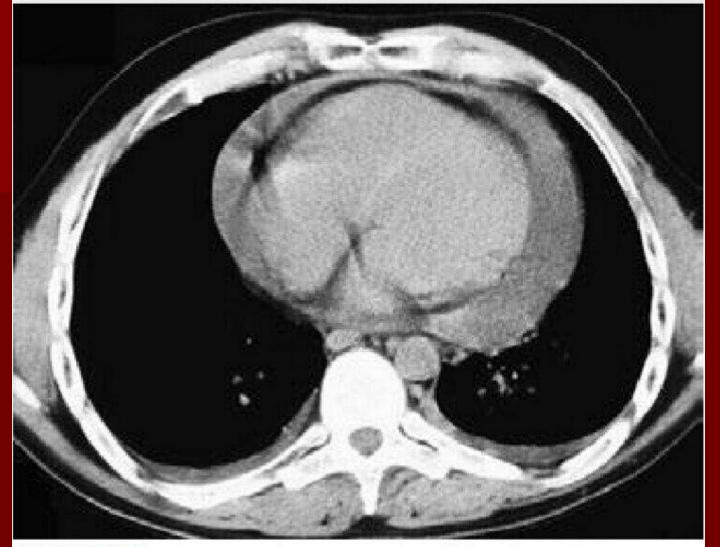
7 Computed tomography of the chest demonstrating a large pericardial effusion in a patient with eosinophilic granulomatosis with polyangiitis (Churg-Strauss). Cardiac involvement is an important cause of morbidity and mortality in eosinophilic granulomatosis with polyangiitis and can include myocarditis, endocarditis, and pericarditis.
